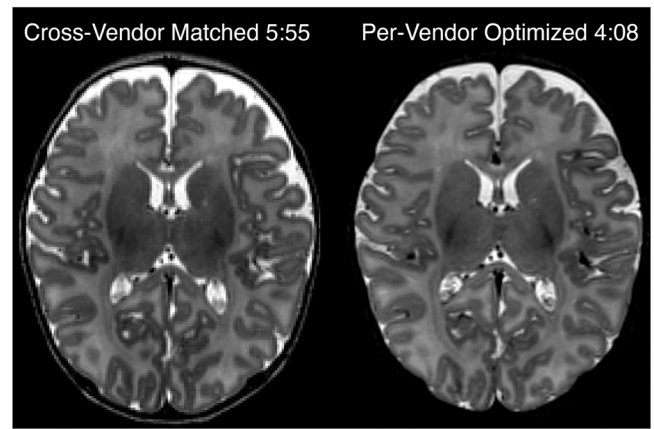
Pilot data, acquired in a 5 week old participant, showing two alternative T2-weighted protocols evaluated during optimization on the Siemens platform. The vendor-matched protocol harmonized TR, TE, and echo train length (ETL) across all vendors. However, due to variations in how each vendor implements variable-flip-angle turbo spin echo, we could achieve equivalent or superior image contrast in shorter time with vendor-specific choices of TR, TE, and ETL.
